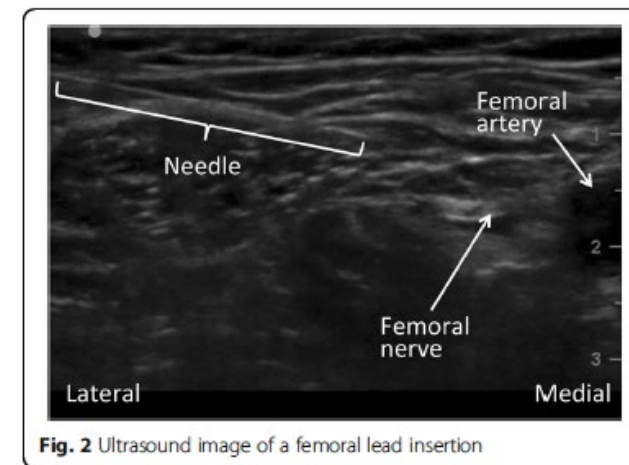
Ultrasound image of a femoral lead insertion
